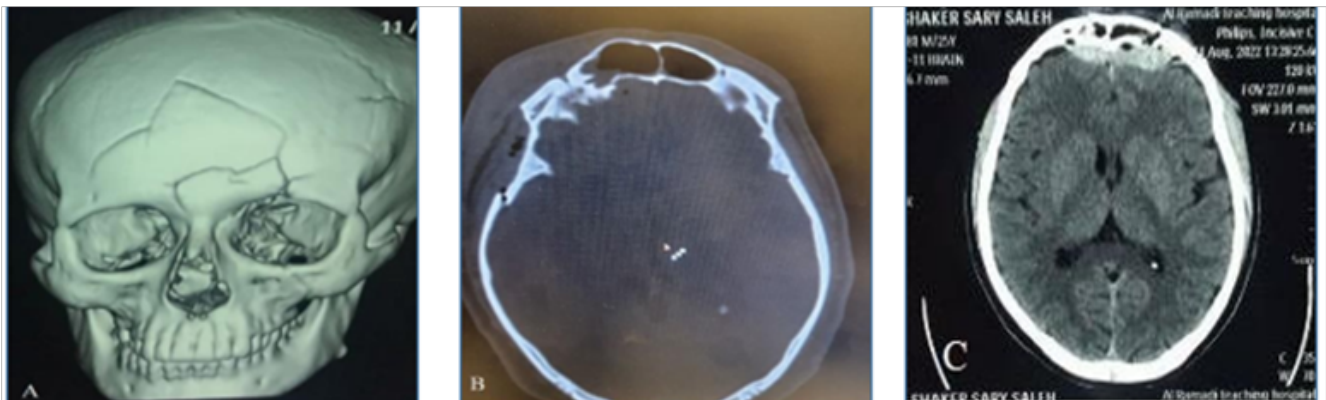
CT scans for different patients with concomitant moderate head injury with maxillofacial trauma.
